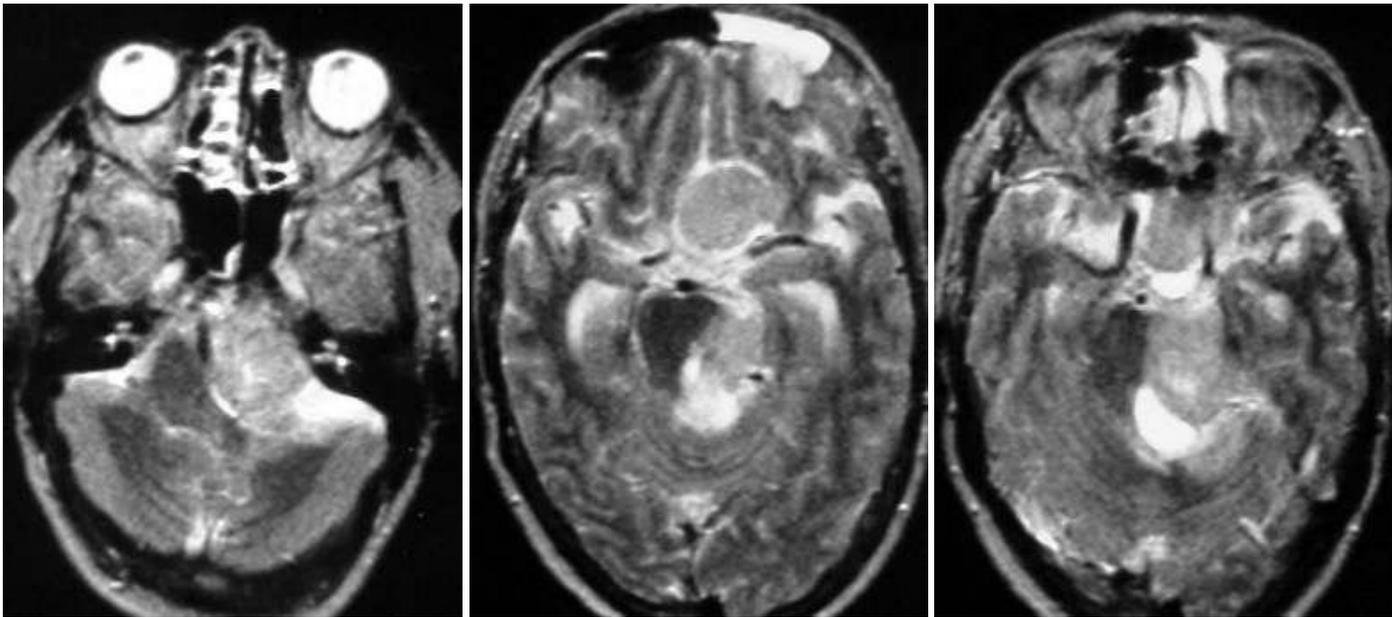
Two syncytial meningiomas. MRI T2 images. The two lesions are hyperintense on the MRI T2 images, and a large cyst is seen in the cerebellopontine angle mass. Both masses are surrounded by a CSF cleft. Notice the arachnoid cyst along the posterior pole of the cerebellopontine angle mass.
